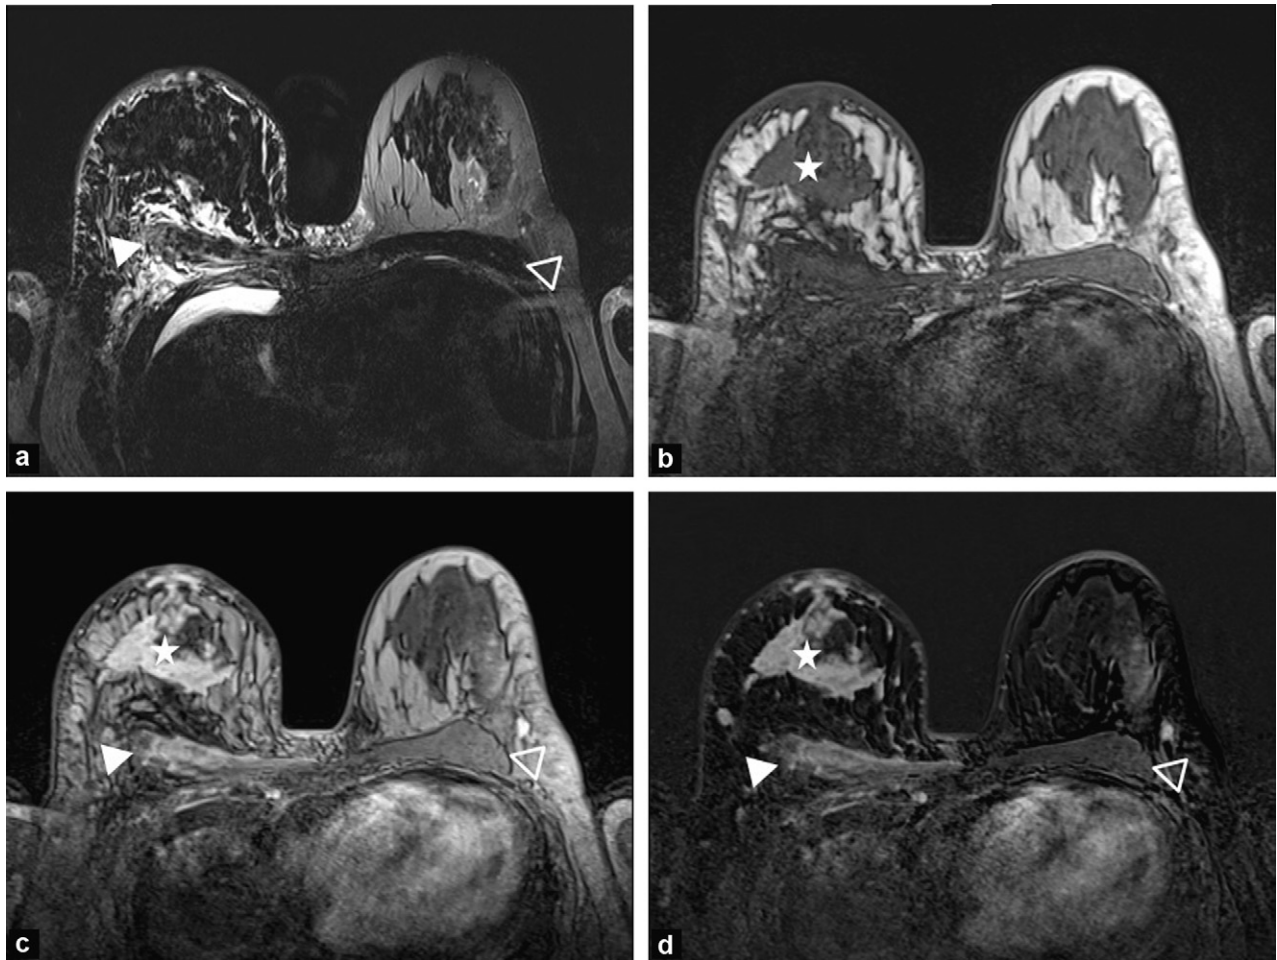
MRI appearance of an infiltrating ductal carcinoma (SBR grade III, triple negative, with P53 mutation) of the right breast, clinically PEV 3. The T2 sequence (a) shows a right pectoralis major muscle hypersignal (solid arrow head), which is asymmetric relative to the left pectoralis major muscle (hollow arrow head). The T1 (b), injected T1 (c) and subtracted injected T1 (d) sequences show enhancement of the pectoralis major muscle which confirms tumour infiltration. These sequences also show the irregularly shaped homogeneous mass with irregular margins (star).
